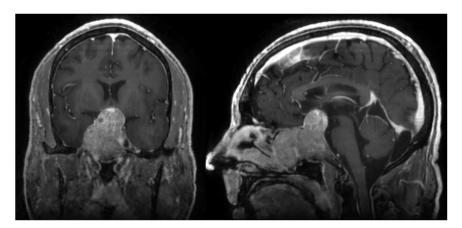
Preoperative T1-weighed postcontrast magnetic resonance imaging demonstrated the extent of invasion of the macroadenoma into the nasal cavity, ethmoid and maxillary sinuses, sellar and suprasellar spaces, and clivus.
